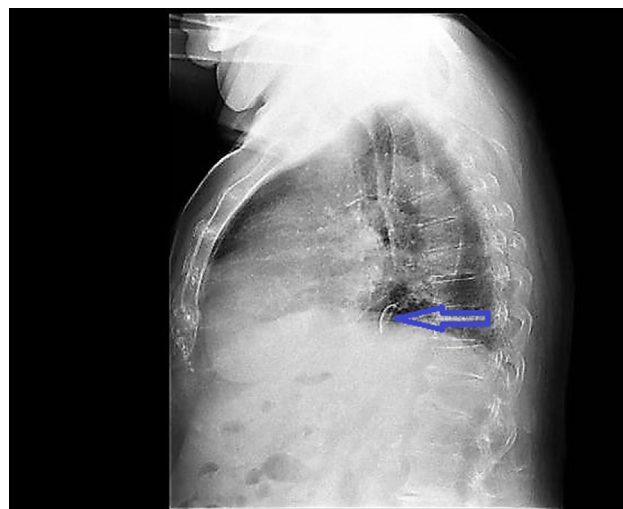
Lateral chest x-ray image of calcium density in the mid-esophagus, in the retrocardiac region, corresponding to a non-metallic foreign body.
